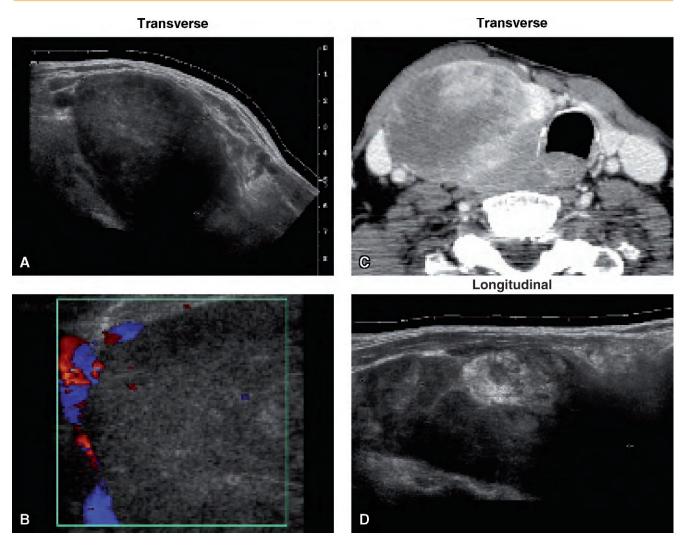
Ultrasound of anaplastic carcinoma in the right lobe. A, Transverse, 46 x 67 mm. B, Color Doppler, Transverse. C, CT Transverse. and D, Longitudinal.
